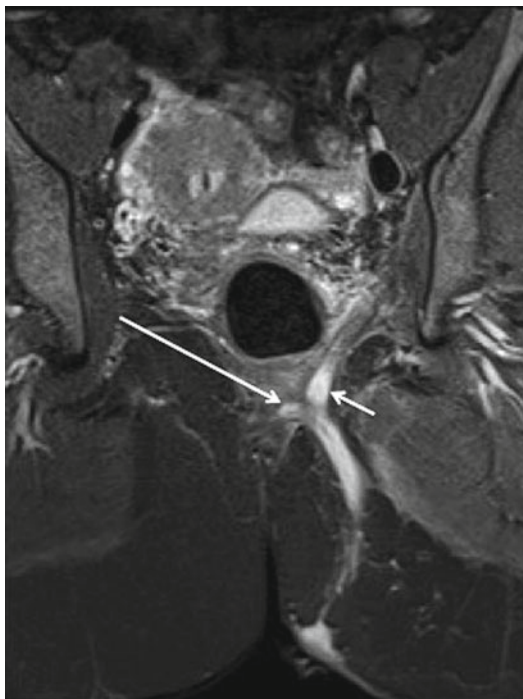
Coronal STIR MRI in a patient with a supra-sphincteric fistula. The primary track is arching over the puborectalis (*long arrow*). There is also a small cranial extension off the apex of the track (*short arrow*) into the roof of the left ischioanal fossa
